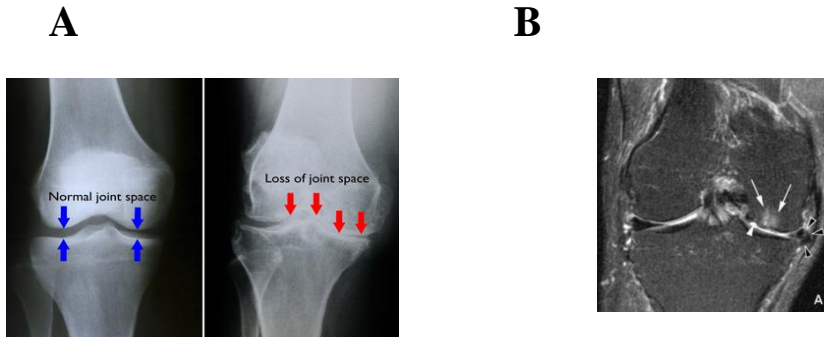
A) Left image represents the X-ray of a normal knee; the space between the bones indicates healthy cartilage (blue arrows). On the right image, an arthritic knee shows severe loss of joint space (red arrows). Image from orthoinfo.aaos.org. B) MRI image shows several features of early OA not detectable by X-ray. White arrowhead shows cartilage defect at central weight bearing part of medial femur. Arrows show subchondral bone marrow lesion. Black arrowheads show meniscal extrusion at medial joint line causing bulging of neighboring medial collateral ligament (no arrow). Image from Guermazi A *et al.* 2012⁵⁴.
